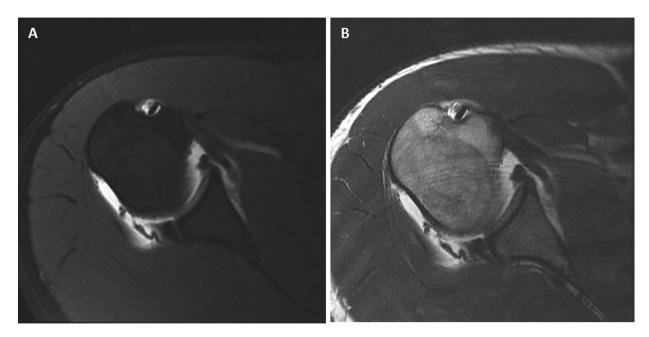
MRI of Kim lesion of the posterior-inferior glenoid labrum. A) Fat saturated TI arthrogram. B) TI arthrogram without fat suppression.
